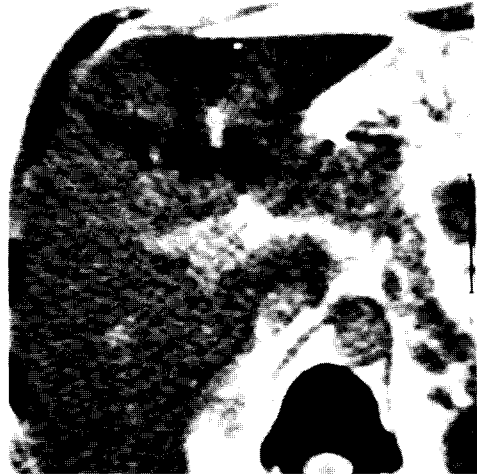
Abdominal computed tomography 10 days after lymphogram demonstrating persistence of contrast medium in the liver.
